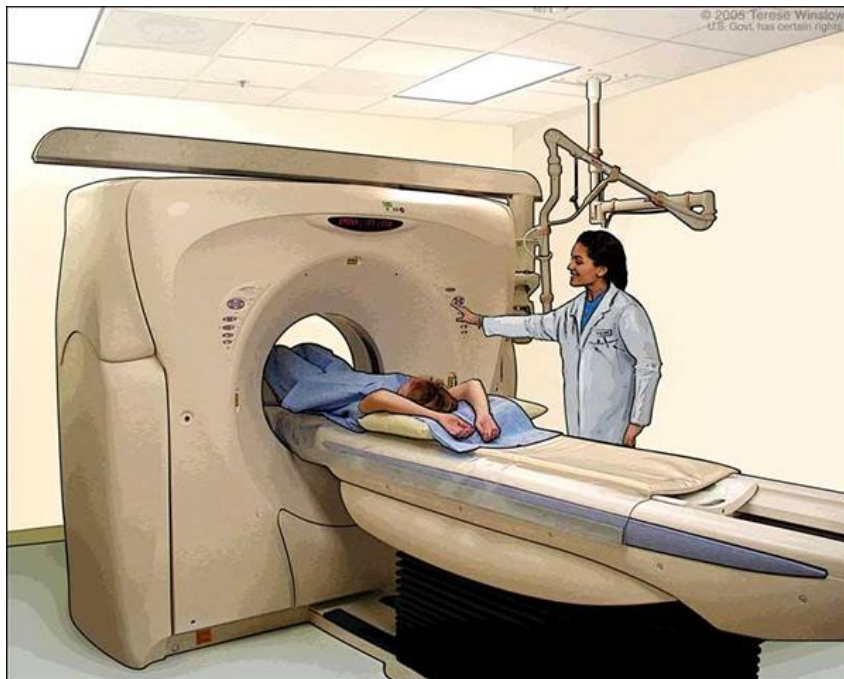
Computed Tomography Scanner(CT). CT scanners are often used in both radiation therapy and brachytherapy to obtain treatment plan information²⁴.
